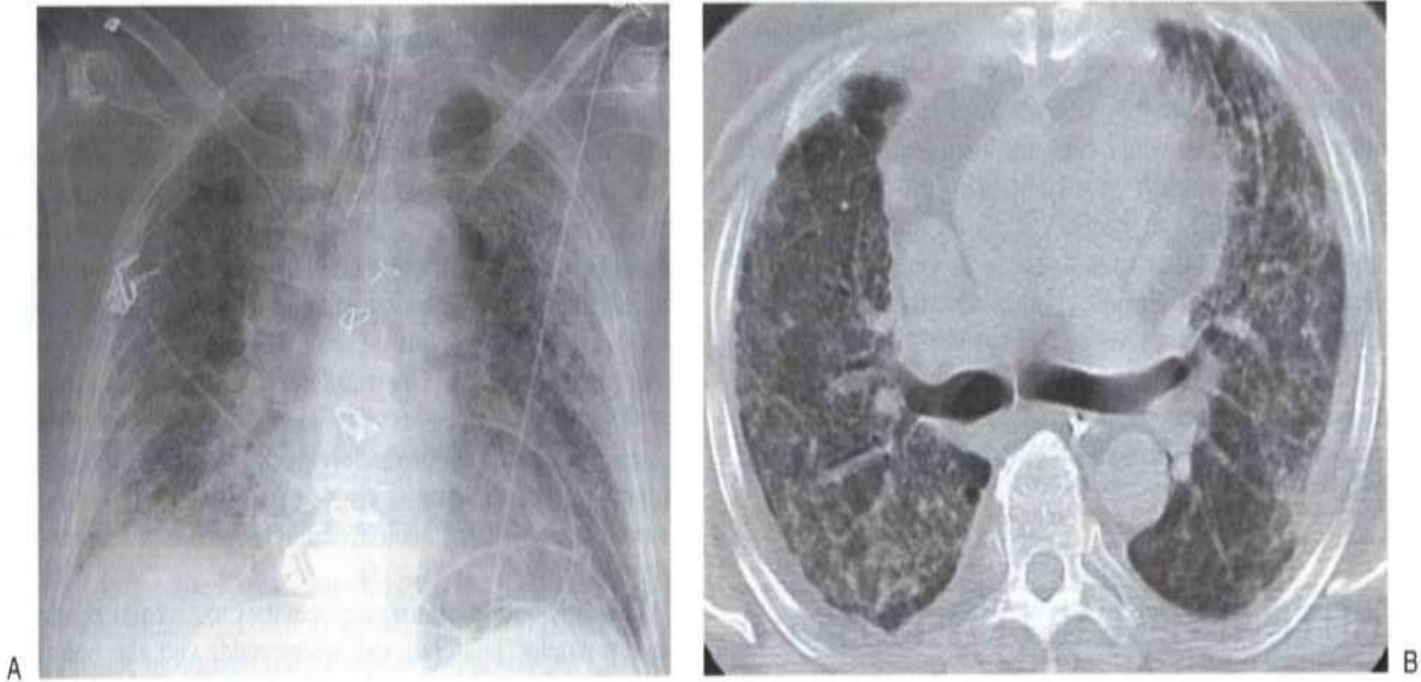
Usual interstitial pneumonia (UIP). A: PA chest radiograph shows medium to coarse reticular ILD with honeycombing, in a predominantly bibasilar and subpleural distribution. Lung volumes are decreased. B: CT scan shows bilateral subpleural honeycombing (dashed arrows), traction bronchiectasis (solid arrows), and a background of ground-glass opacity.
